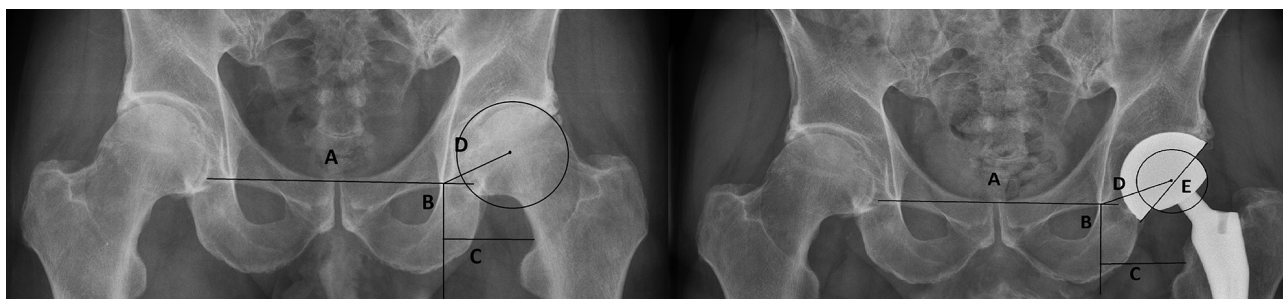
Left picture. Measurement performed on the pre-operative X-ray after calibration. First a line was drawn through the inferior aspect of the teardrop on both sides (A). A perpendicular line was drawn from the inferior aspect of the teardrop (B). On line B a line perpendicular was drawn till the superior part of the trochanter minor (C). Line B is called the Lower Limb Length and line C is the lateral offset. A perfect circle was drawn in the acetabulum. The center of this circle the center point of rotation. From this point a line is drawn to the superior aspect of the teardrop (D) this line is called the Center of Rotation Distance (CORD).
